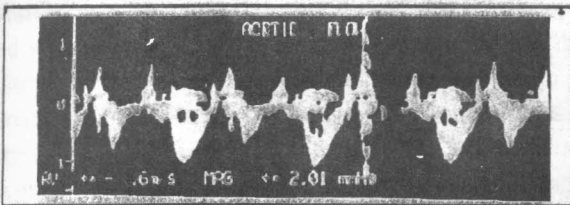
Pulsed wave Doppler recording of the aortic velocity in a normal subject.
